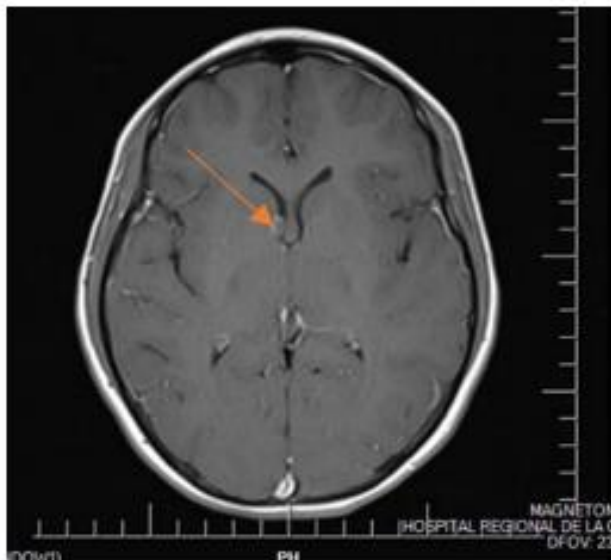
Brain MRI. Focal lesions in left frontal subcortical topography and right basal frontal periependymal in different evolutionary stages.
